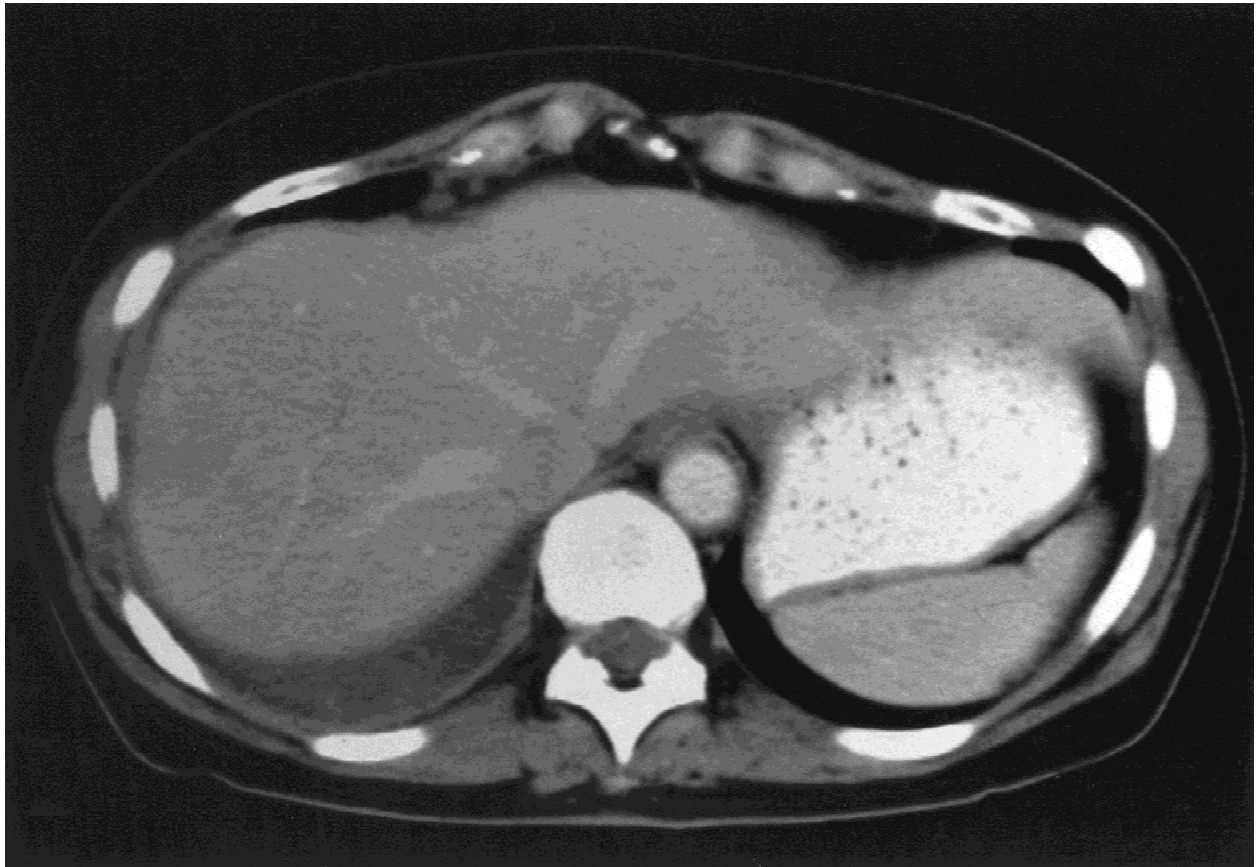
CT showing mucinous tumor surrounding the liver.
